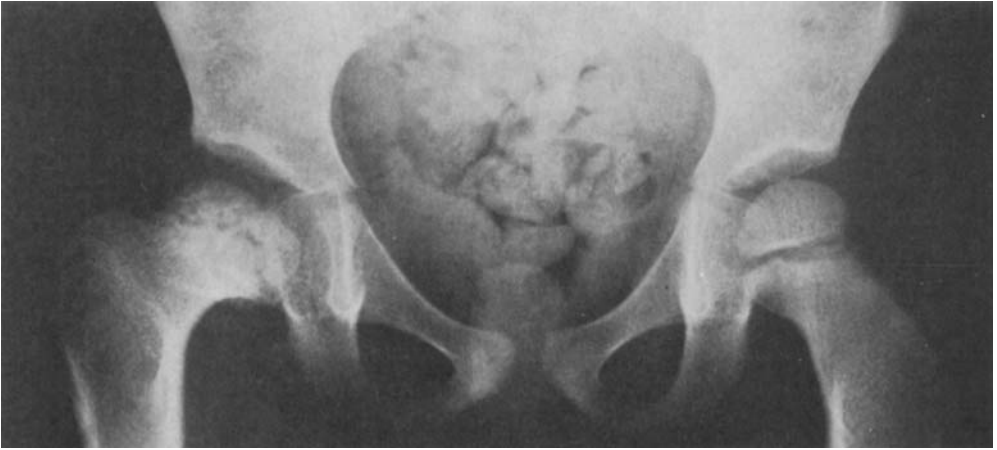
III. 760814, M.L. No notes from the first examination at birth. Examination at 6 weeks at the Child Health Centre: instability of the right hip joint. No radiographic examination. Treatment: no traction therapy, no tenotomy; von Rosen splint for 9 weeks. Check-ups after 2 and 5 weeks and after termination of treatment were normal. Radiographic examination at 8 months: still somewhat smaller nucleus of the femoral head, no displacement. At 14 months: avascular necrosis of the femoral head and neck. Follow-up at 4 years and 9 months: severe sequelae of necrosis, coxa plana and coxa vara (Fig.).
